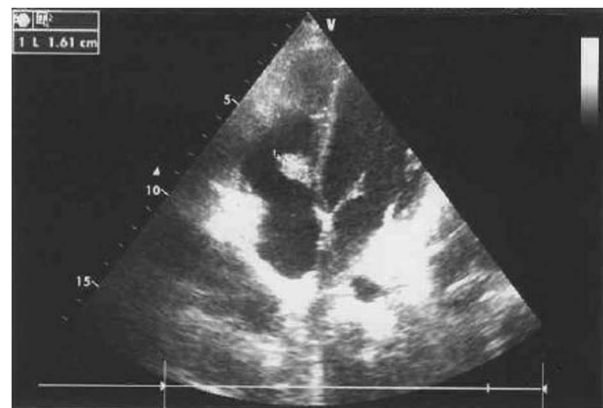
Abnormal mass adjacent to the tricuspid septal leaflet on echocardiography.
